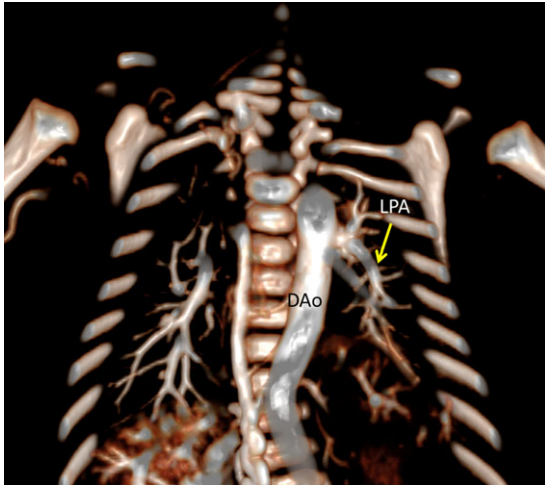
CT imaging showing the left pulmonary artery (LPA) arising from descending aorta. Three-dimensional frontal CT angiogram with LPA (*) arising from the lateral surface of the descending aorta (DAo)
